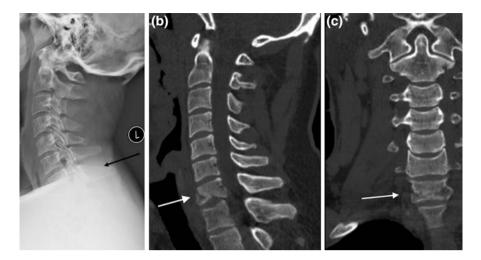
Diagnostic advantage of CT over radiographs. Patient with history of trauma and neck pain. In the lateral view radiograph of the cervical spine (a), patient's injury is not well seen (at level of *black arrow*). Sagittal (b) and coronal (c) reformatted images from patient's CT scan demonstrates comminuted fracturing of the C7 vertebra (*white arrows*)
